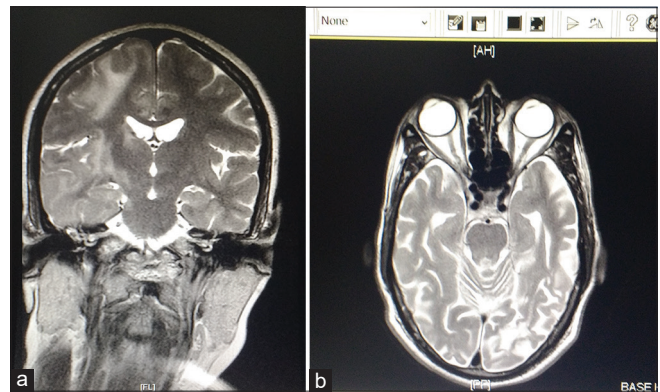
A 48-year-old man presented with subacute progressive cognitive decline and loss of vision. Magnetic resonance imaging revealed asymmetric T2 and fluid-attenuated inversion recovery hyperintensities in deep periventricular white matter in bilateral parietal and left occipital lobes with no mass effect, no contrast enhancement, and no true restriction on diffusion-weighted imaging. (a) MRI Brain Coronal section T2 Weighted image (b) MRI Brain Axial section T2 weighted image
